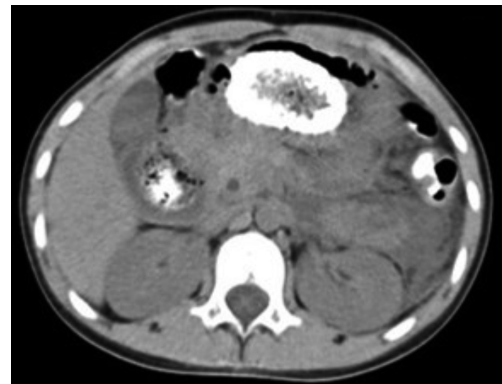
CT scan imaging. Plain scan imaging shows mixed high-density and gas-density masses in the gastric body and pylorus. CT, computed tomography.
